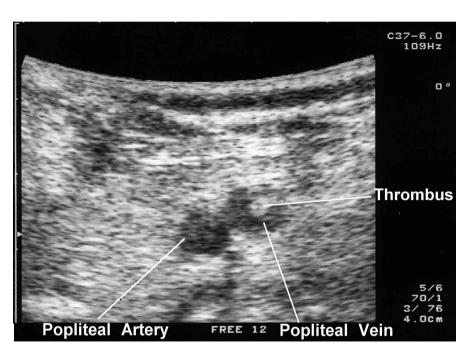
Ultrasound of left popliteal veins.
